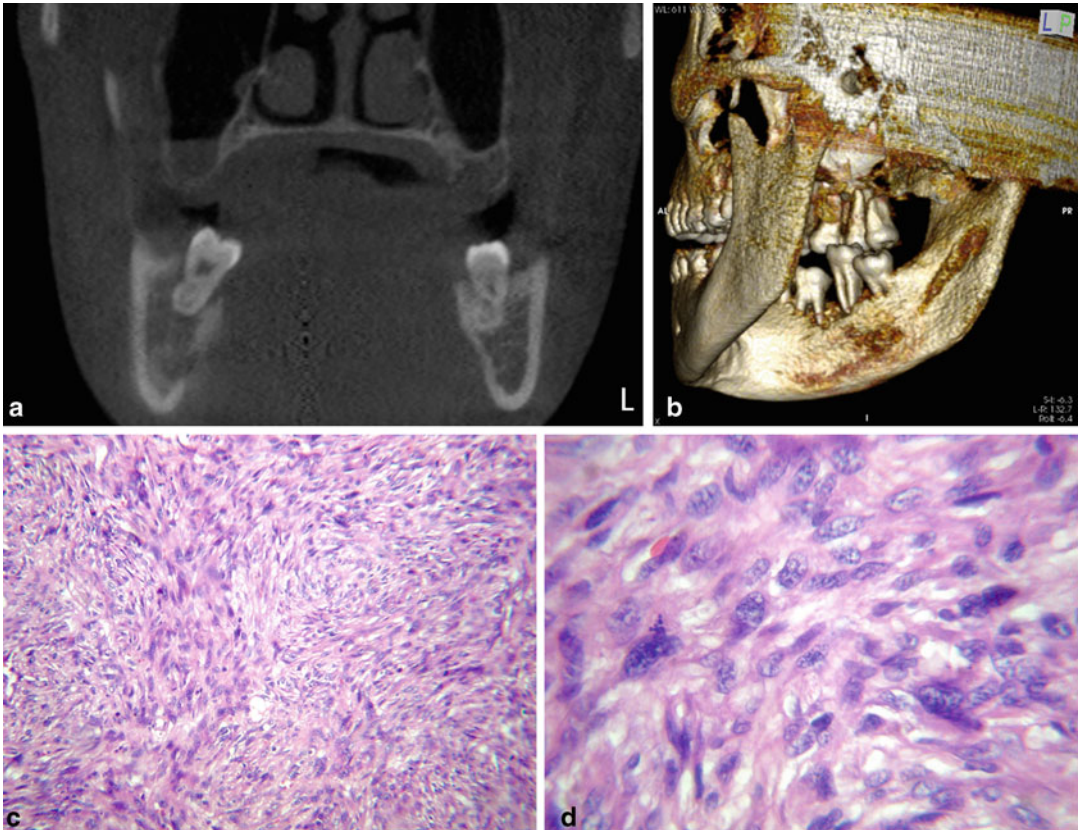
Fibrosarcoma. CT of large soft tissue mass extending from the floor of the mouth, affecting the right side of the tongue, altering the air spaces, and invading the right mandibular bone (a) causing irregular osteolytic destruction affecting dental support (b). Intermediate (c)
